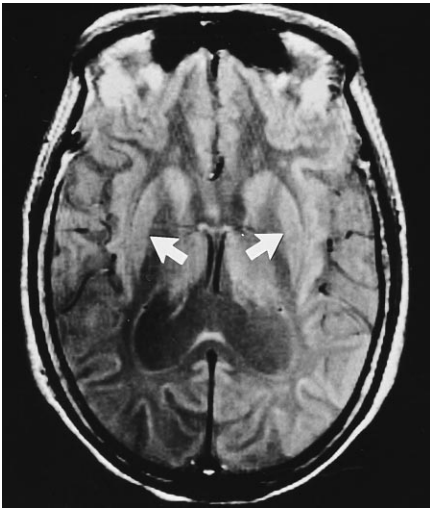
Proton density-weighted MR image (3000/15/1) of a different patient shows symmetric, bilateral atrophy in putamen (arrows).
